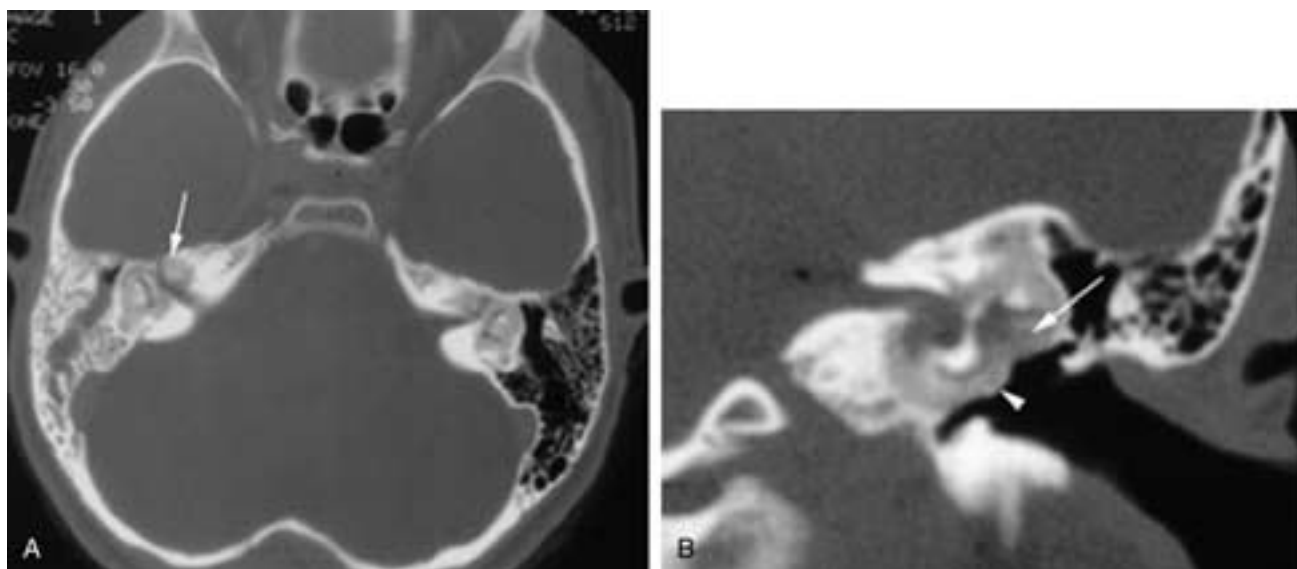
Osteogenesis imperfecta. A, Axial CT image shows the gross demineralization of the otic capsule (*arrow*). B, Coronal image shows thickening of the bone as well as the demineralization. Note the thickness of the bone over the promontory (*arrowhead*) and in the region of the tympanic segment of the facial nerve canal (*arrow*). The patient presented with a conductive hearing loss and facial paralysis.
